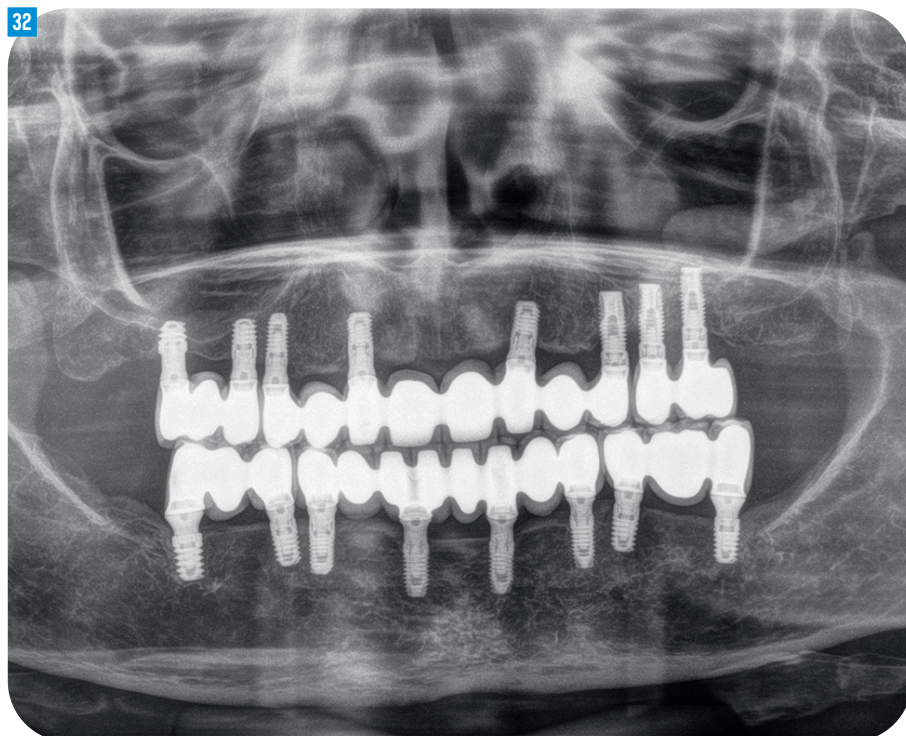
Panoramic radiograph of the completed final rehabilitation, divided into three sections in both the mandible and the maxilla
